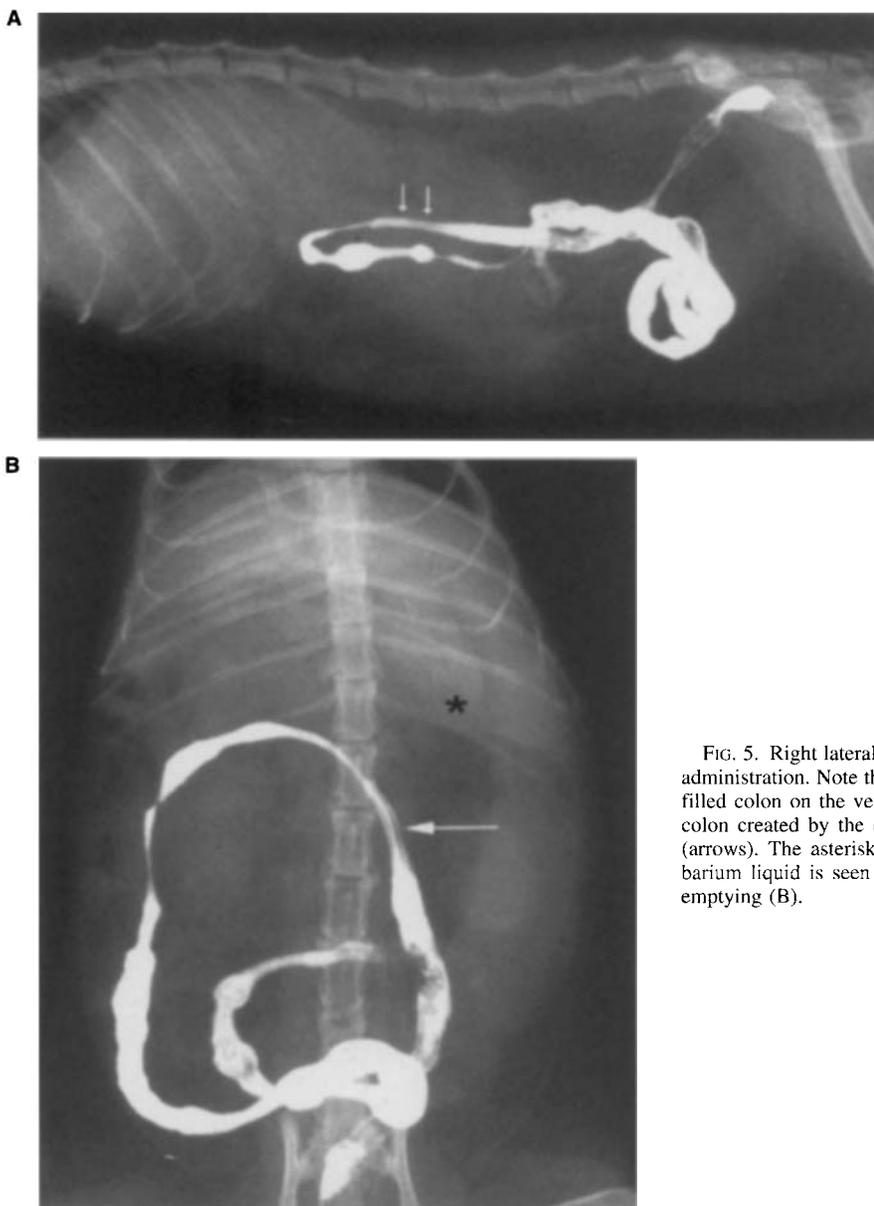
Right lateral (A) and VD (B) radiographs obtained 1 h after barium administration. Note the curved question mark-like appearance of the barium-filled colon on the ventrodorsal view. The longitudinal filling defects in the colon created by the colonic mucosal folds are evident on both projections (arrows). The asterisk in (B) identifies the stomach. A minimal amount of barium liquid is seen adhering to the gastric mucosa after complete gastric emptying (B).
